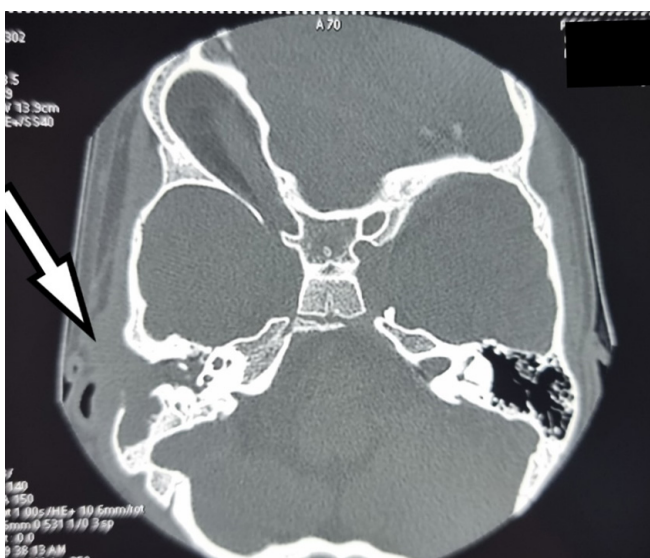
CT of the endocranium: semisolid content of dense attenuation completely fills the right tympanic cavity with an enlarged mastoid antrum and content that fills the entire right mastoid
